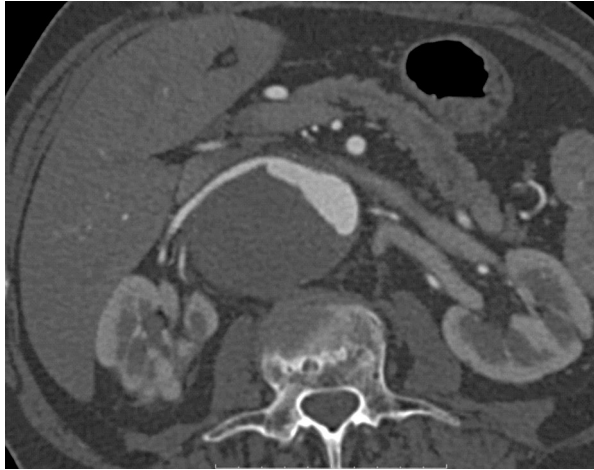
Preoperative CT scan presents blood supply via massive thrombus inside the aneurysm
